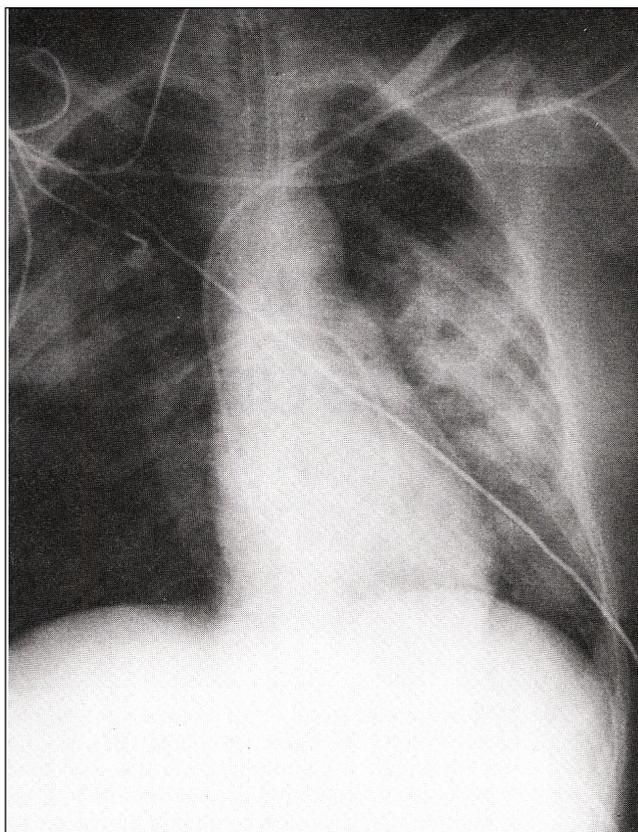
Chest radiograph of case 1. This radiograph was taken about 4 h after the one shown in Figure 1. Note there is more extensive involvement of the right lung
